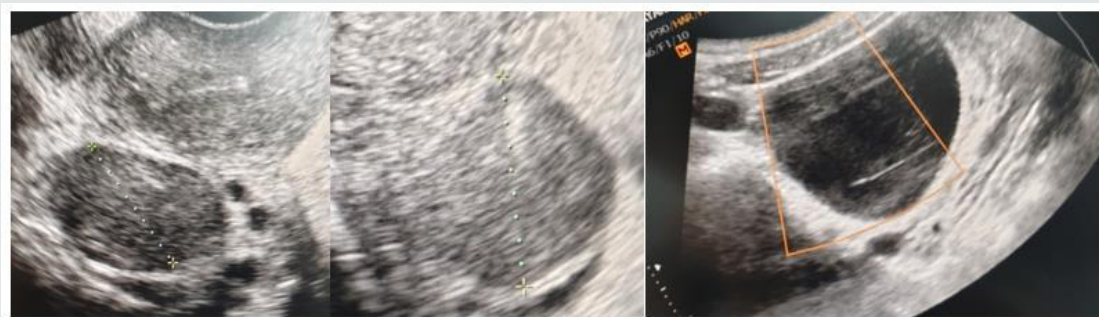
Ultrasound image showing endometrioma on the on the right ovary before pregnancy. endometrioma (arrow) with homogeneous low-level echoes no color flow will be seen and luteinque cyst on the left ovary.
